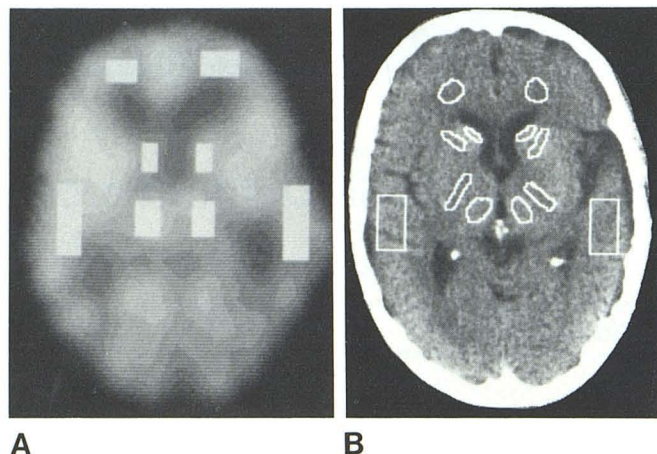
A, Representative PET scan depicts regions of brain sampled for metabolic study. B, Representative CT scan depicts regions of brain evaluated in structural attenuation study.
